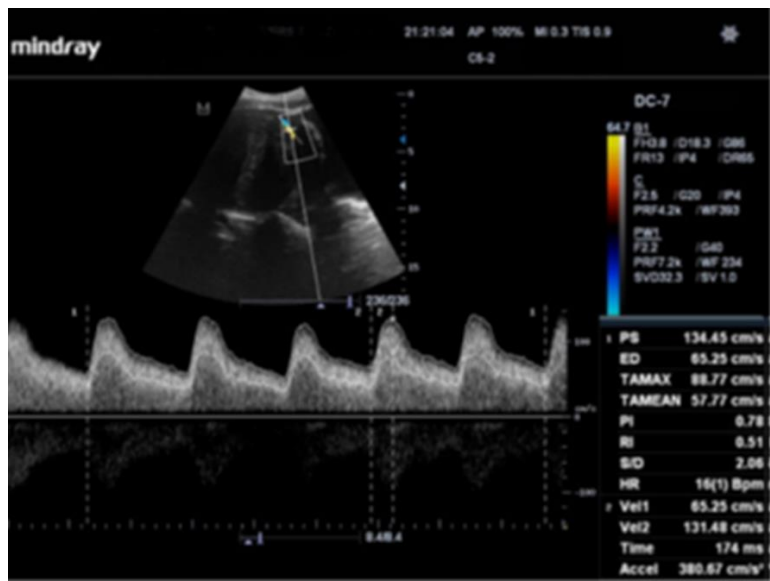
a. Longitudinal triplex sonogram of a myomatous uterus showing the waveform pattern and Doppler indices of a perifibroid (peripheral) artery. (Idowu BM et al 2018)
